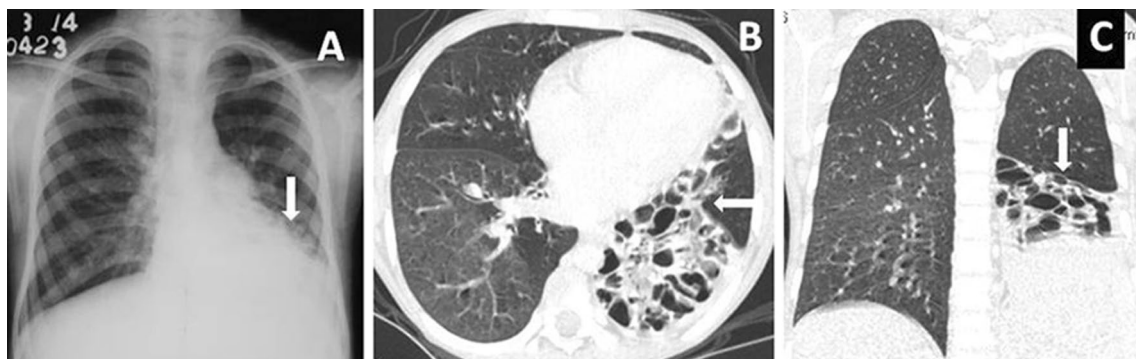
Bacterial Infection. An 11-year-old-HIV-positive male patient presented with cough & fever since 15 days. CXR-posteroanterior (PA) view reveals a homogenous opacity involving left lower zone causing silhouetting of left cardiac border and left hemi-diaphragm (arrow, A). CT chest shows left lower lobe and lingular atelecto-bronchiectatic changes (arrow in B,C) with ipsilateral mediastinal shift and upward displacement of the left hemi-diaphragm. Sputum could not isolate any microorganism. CD4 count was 248 cells/cu.mm. Patient was given antibacterial antibiotics and improved clinically over a period of 2 weeks
